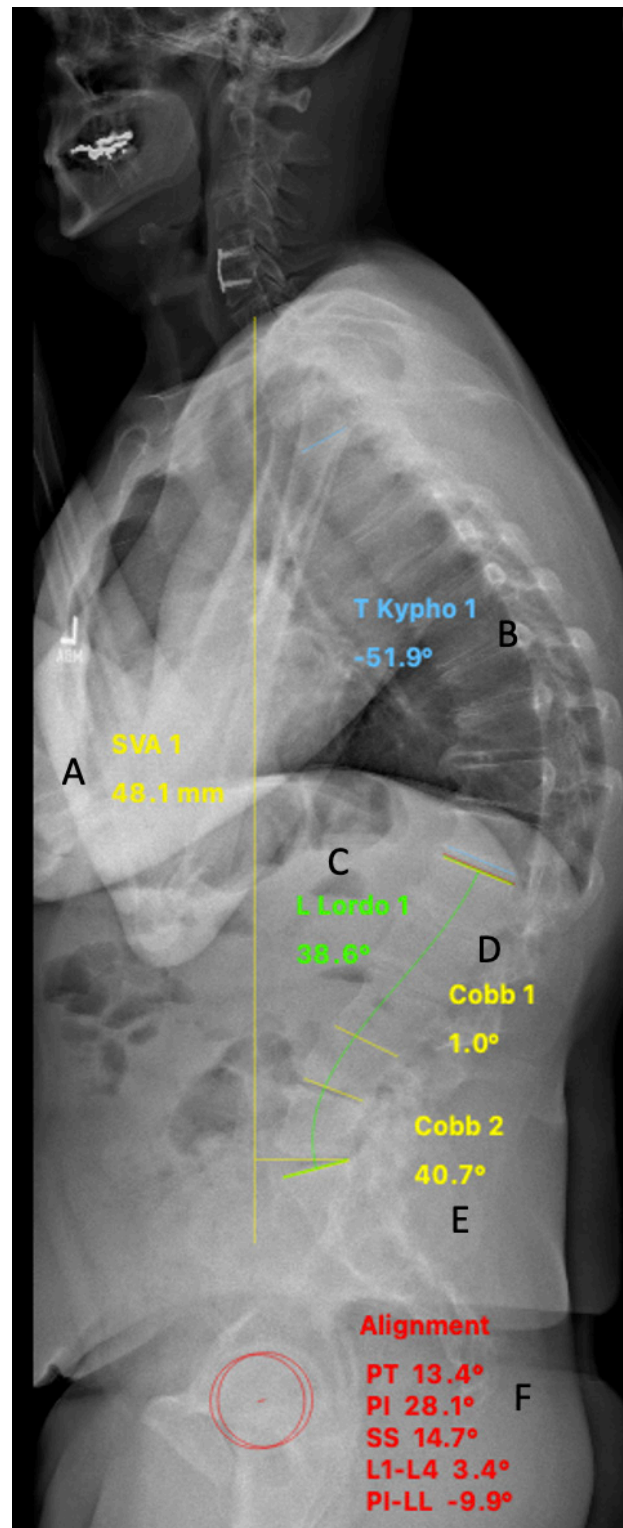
Example of radiographic measurements. (A) Sagittal vertical axis (SVA) measured as the distance from the posterosuperior corner of S1 horizontally to a vertical line dropped from the center of the C7 vertebral body. (B) T4-12 kyphosis measured from the cranial endplate of T4 to the caudal endplate of T12. (C) L1-S1 lordosis measured from the superior endplate of L1 to the superior endplate of S1. (D) L1-4 lordosis measured from the cranial endplate of L1 to the caudal endplate of L4. (E) L4-S1 lordosis measured from the cranial endplate of L4 to the cranial endplate of S1. (F) PI-LL tool using the femoral heads and the cranial endplates of L1 and S1 to calculate pelvic tilt (PT), pelvic incidence (PI), and sacral slope (SS).
